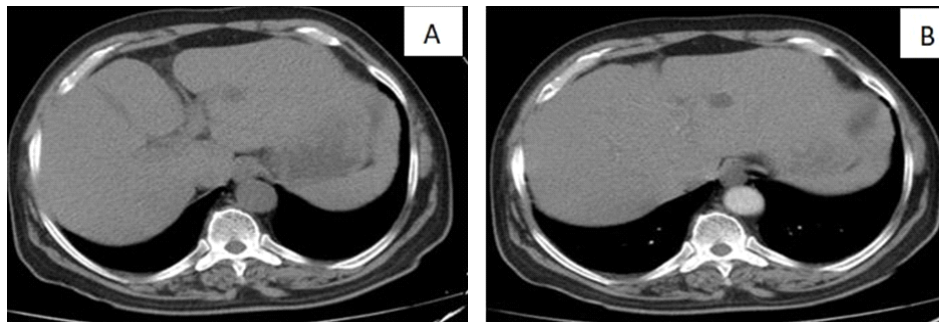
A) Non enhanced CT images of liver showing a cystic lesion. B) Contrast enhanced CT image of simple cyst
